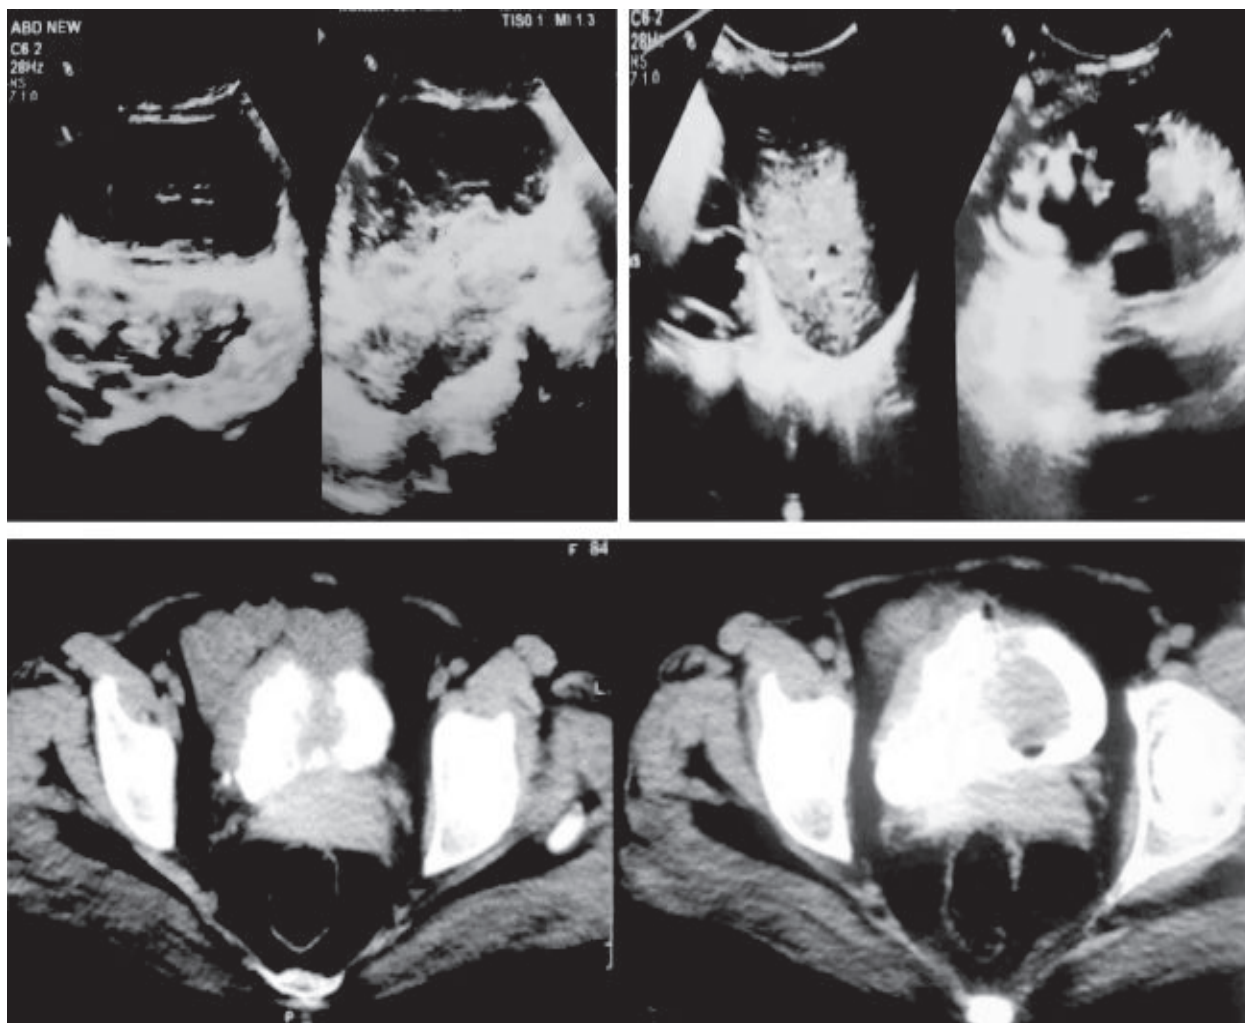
& 2b (Top images): Showing Transabdominal USG scan and Fig 2a & 2b (bottom images): axial CT images of Cervical growth invading bladder wall with bilateral hydronephrosis.
